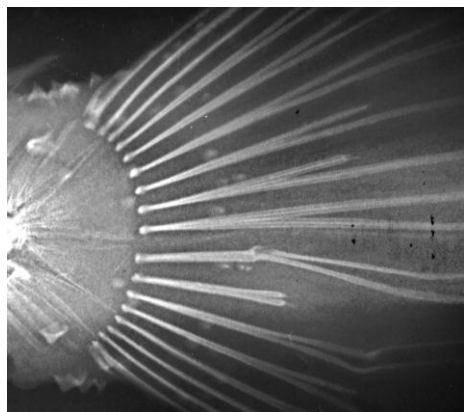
X-ray photo of the eroded caudal fin of BST. Male, TL 51.6, SL 41.7 cm, 2010.06.03, 44°41'22"N, 33°25'24"E
